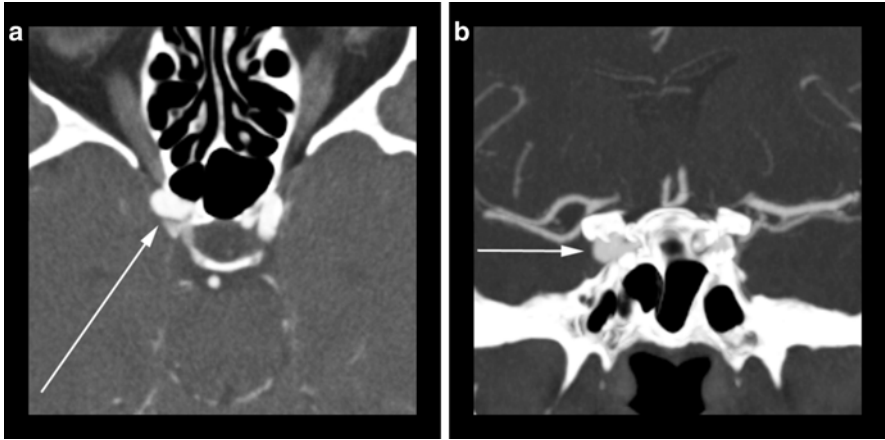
55-year-old male presenting with stroke-like symptoms. (a) Axial CTA image reveals abnormal dilatation (*arrow*) of the cavernous segment of the right internal carotid artery. (b) A coronal CTA MIP image better displays the aneurysm (*arrow*) of the cavernous segment of the right internal carotid artery
